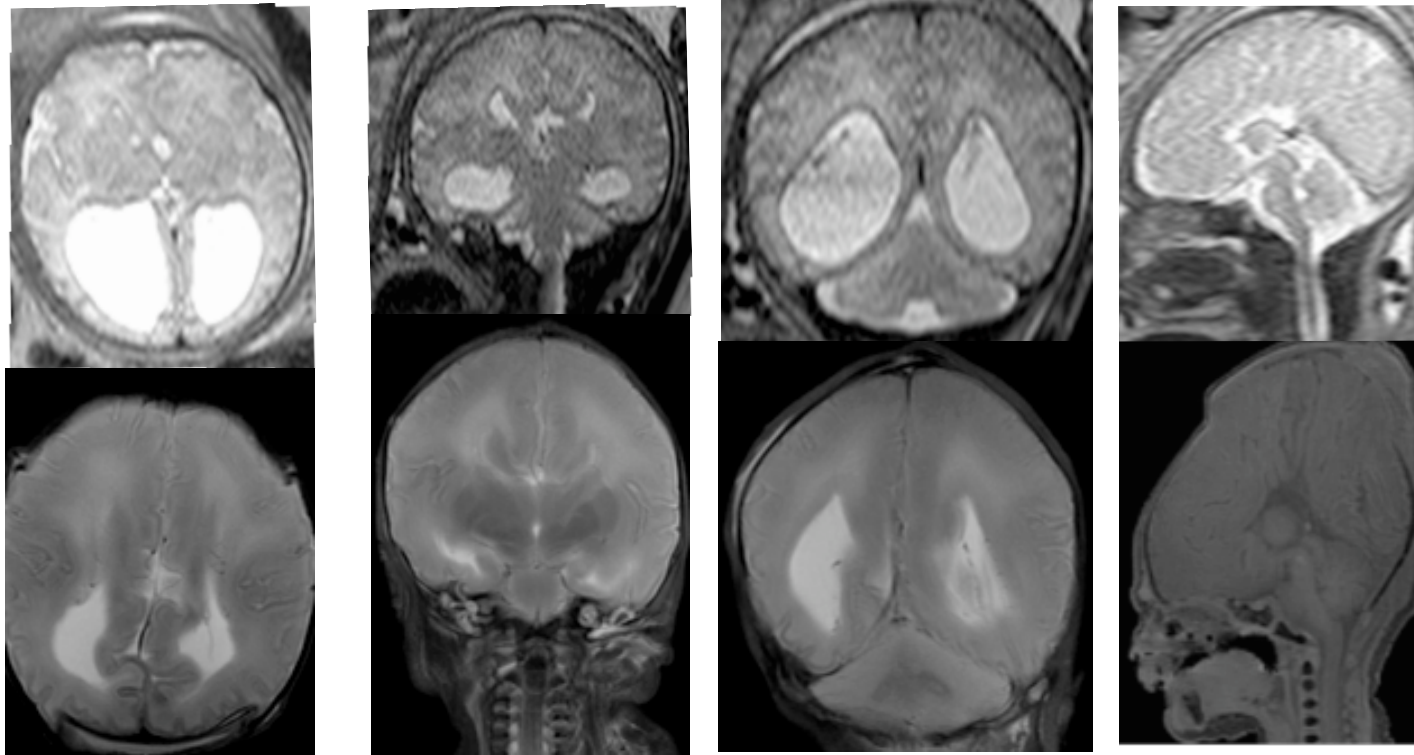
Ante-mortem and post-mortem MR imaging in neonatal encephalopathy
